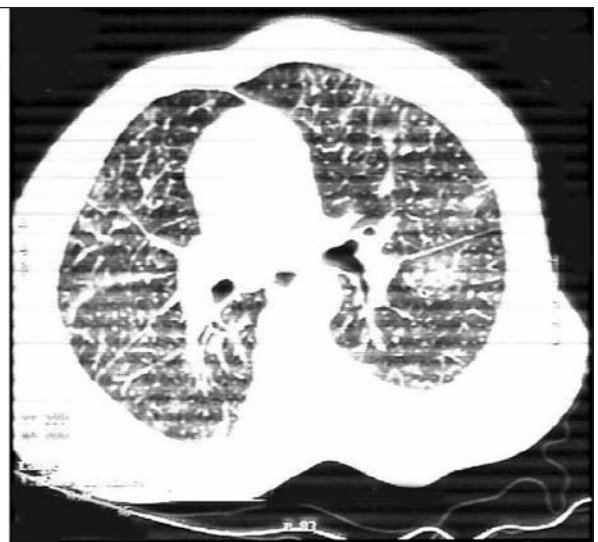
Thorax HRCT revealed ground glass densities in some areas, widespread interlobular septal thickening, peribronchial thickening predominantly perihilar in both lungs and many small subpleural nodules with metallic density, and end-stage fibrosis.
